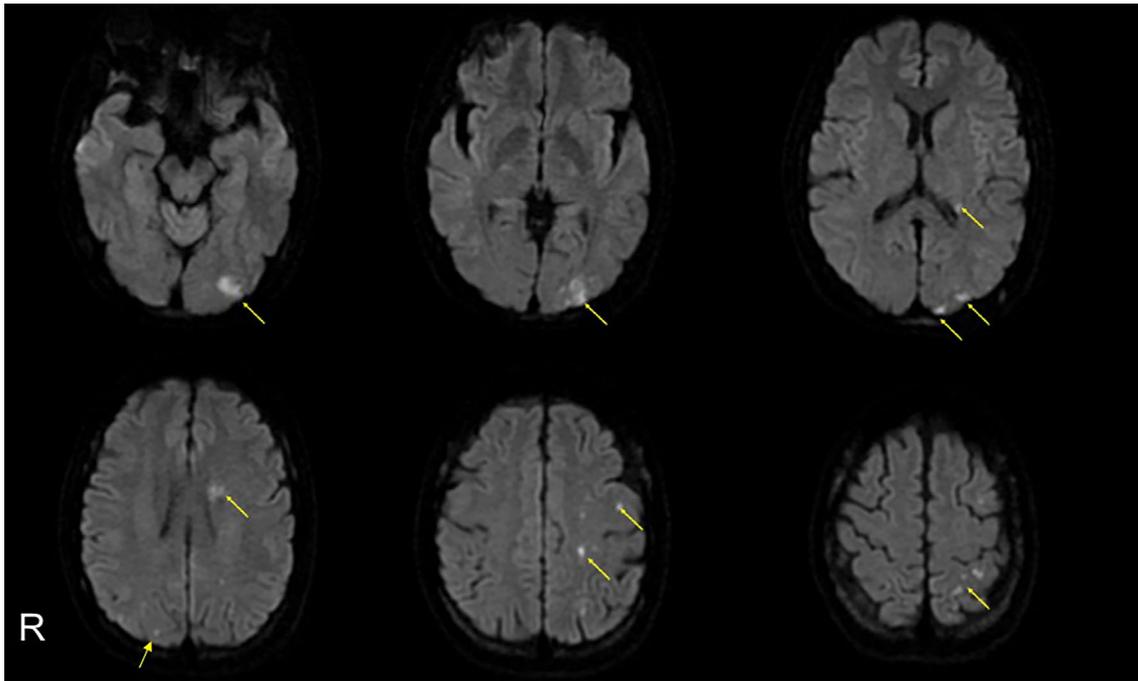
Brain magnetic resonance imaging on admission shows multiple acute infarctions predominantly in the watershed area of the left hemisphere (arrows).
